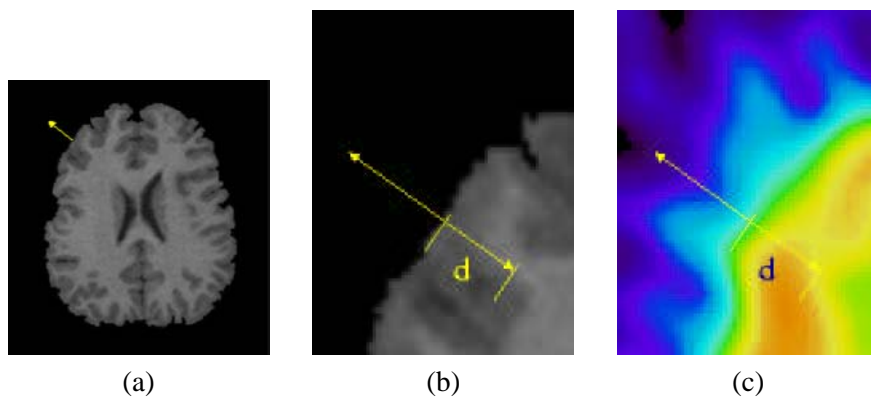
a) Segmented MRI with b) normal and c) PET with the same normal and depth to be checked. See page 67 for a colour version of the figure.
